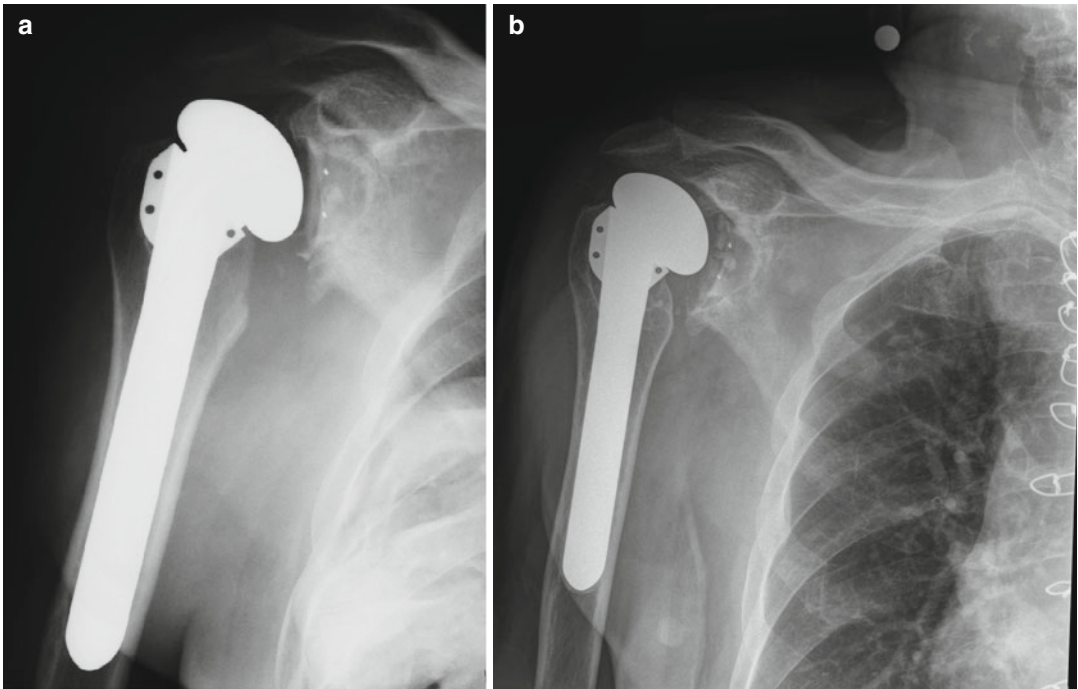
Total shoulder arthroplasty in a patient with haemophilic arthropathy. (a) AP radiograph two years after surgery. (b) 5 years after surgery there is obvious
